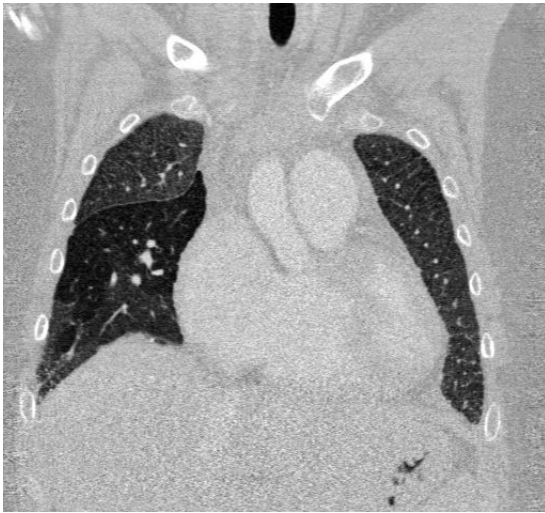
CT scan image of a patient, (left) original image, (right) image after segmentation of lung parenchyma. Color coding: dark green = right lung, light green = left lung.
